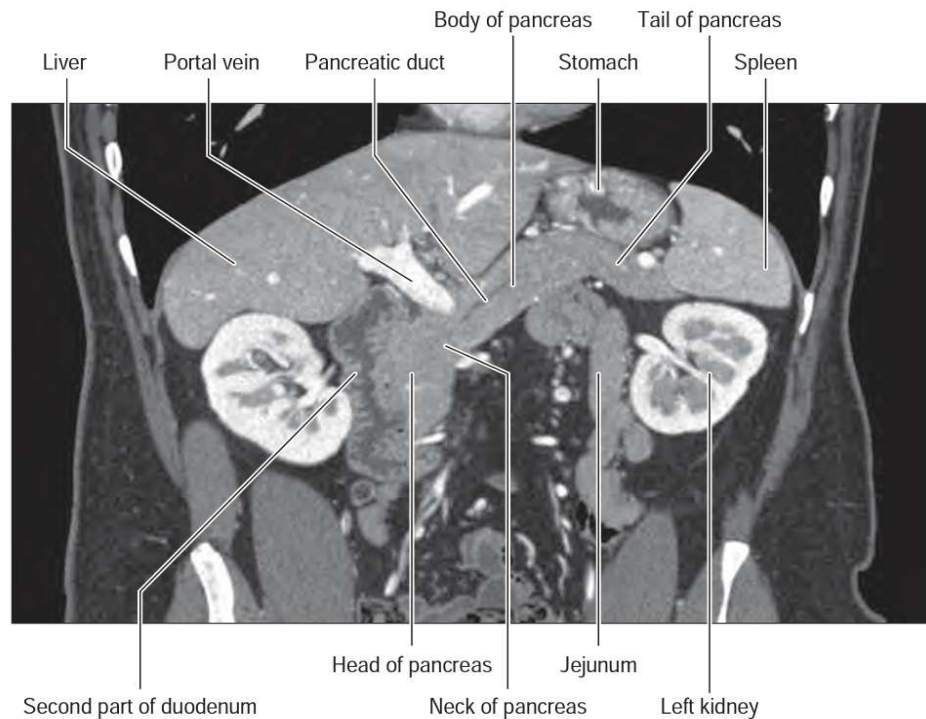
coronal-reversed computed tomogram, the pancreas can be seen in context with other organs in the upper abdomen.
